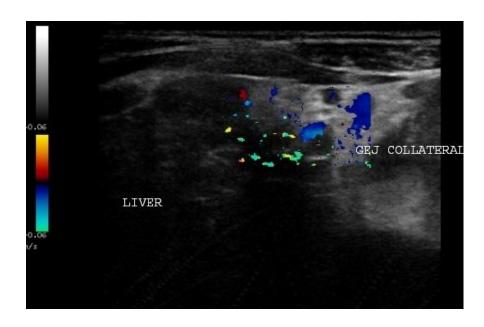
Colour Doppler USG Image showing Gastro-Esophageal Junction (GEJ) collaterals.
